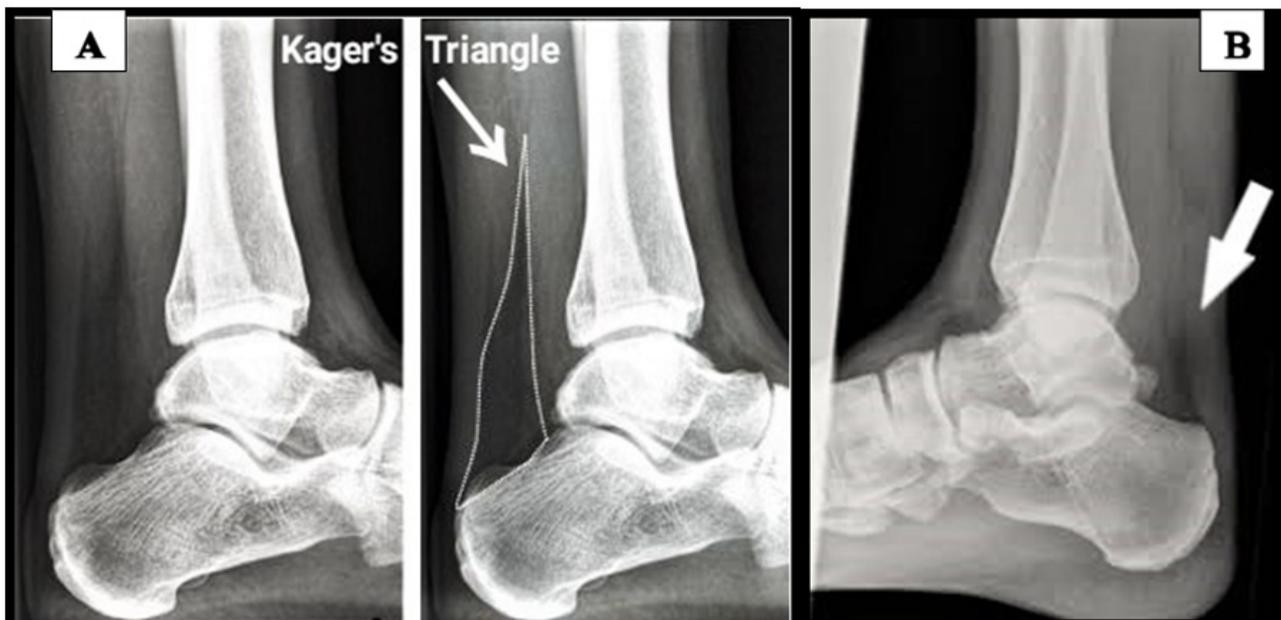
Radiographs showing A. Kager's Triangle (Normal) and B. Obliterated in TA Tears
